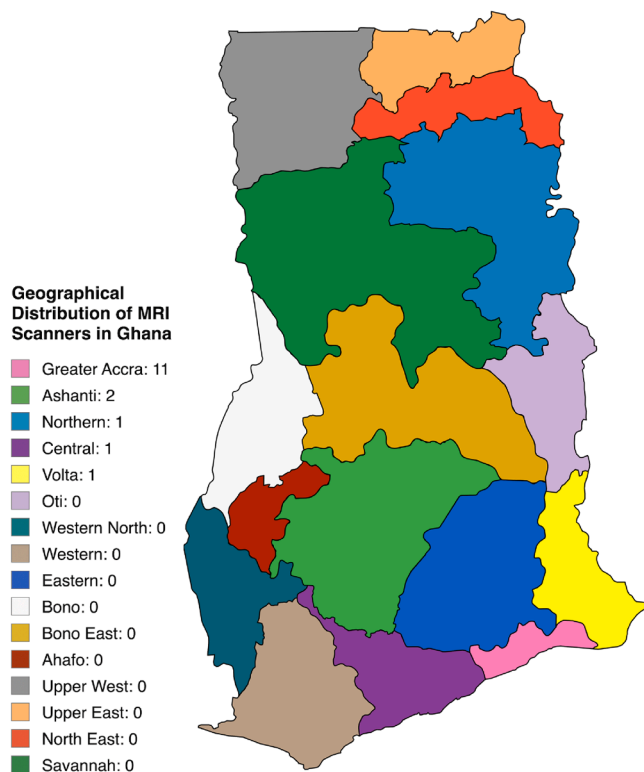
Geographical Distribution of MRI Scanners in Ghana. Most MRI scanners located in the Greater Accra region.
